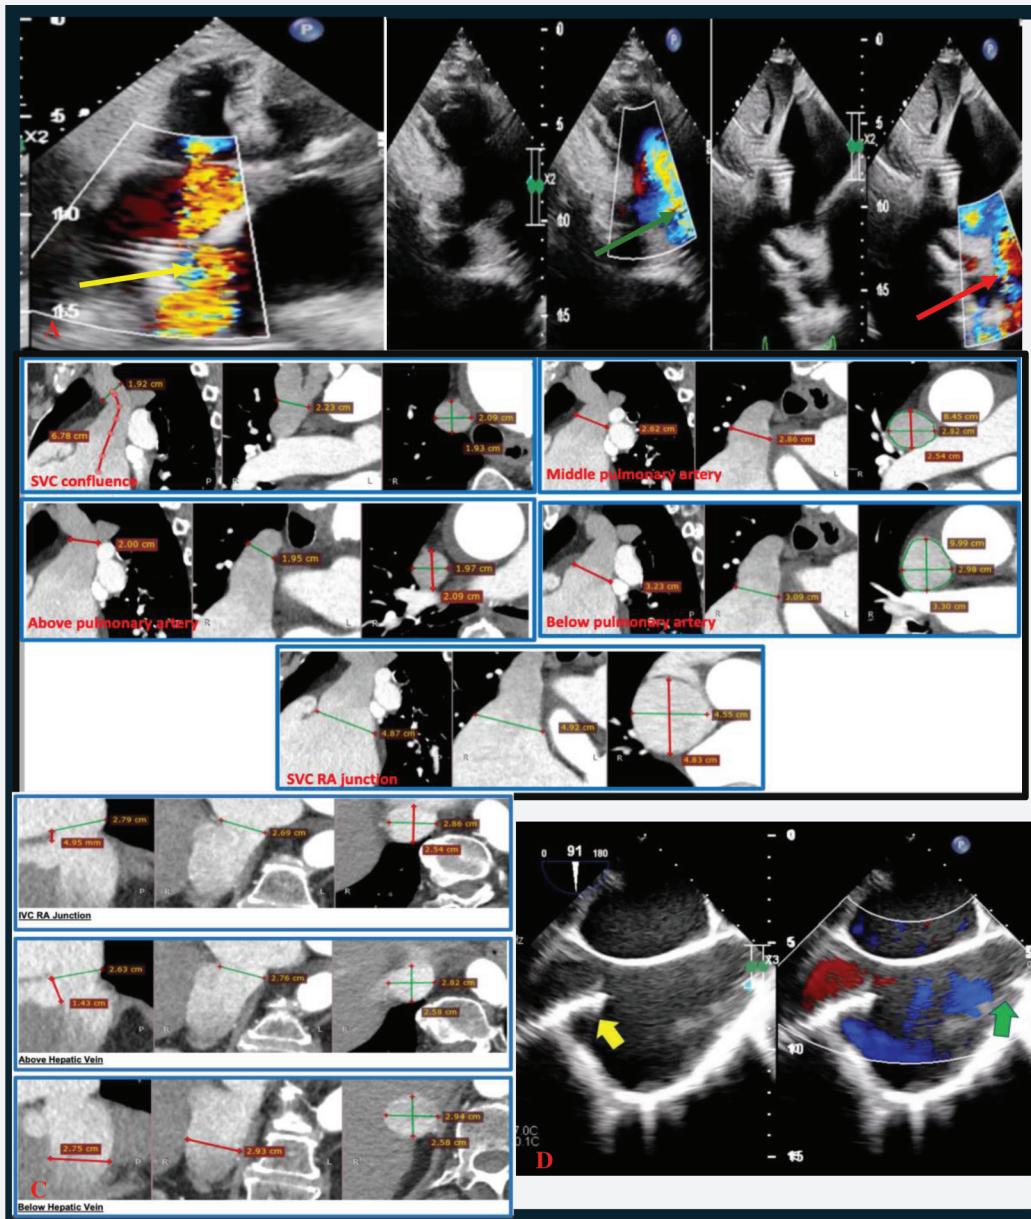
(A). Transthoracic echocardiogram showing severe TR (yellow arrow) in apical 4 chamber view, RV inflow view demonstrating reflux to the inferior vena cava (green arrow), subcostal bi-caval view demonstrating reflux to the superior vena cava (red arrow); (B). CT venogram measurements for the SVC showing SVC confluence diameter (19 mm), SVC at the level of above the PA diameter (21 mm), SVC at the level of the middle of PA diameter (26 mm), SVC at the level of the bottom of the PA diameter (33 mm), and length of confluence to SVC-RA junction (68 mm); (C). CT venogram measurements for the IVC showing IVC-RA junction diameter (26 mm), IVC above the hepatic vein (HV) diameter (27 mm), IVC just below the HV diameter (27 mm), HV distance is 4.95 mm below the IVC-RA junction, HV ostium diameter (14 mm);(D). TEE post CAVI demonstrating the IVC prosthesis (yellow arrow) and SVC prosthesis (green arrow) anchored to the right atrium and with no paravalvular leaks.
